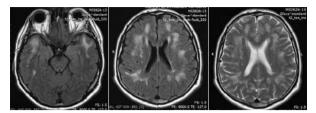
Multiple confluent changes of increased intensity on T2 and FLAIR, localized temporopolarly, periventricularly and in the deep subcortical white matter, with several lacunar lesions of the same MRI characteristics *Slika 2.* Višestruke i slivene promene povišenog intenziteta signala u T2 i FLAIR, lokalizovane temporopolarno, periventrikularno i u dubokoj supkortikalnoj beloj masi, sa nekoliko lakunarnih lezija istih karakteristika na snimcima magnetne rezonancije
